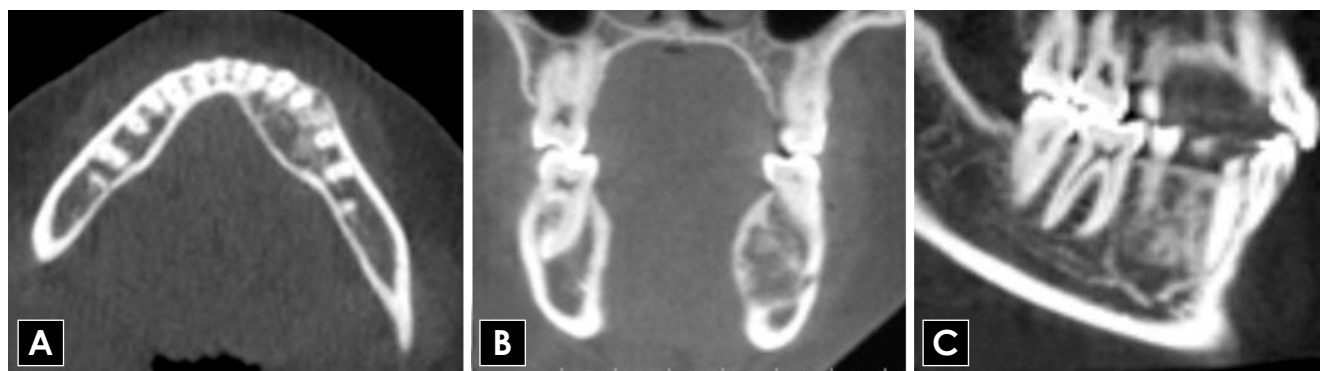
Axial (A), coronal (B), and sagittal (C) CBCT images of a hybrid CGCG with COF lesion in the left premolar region of the mandible with a well-defined, mixed-density appearance. CBCT: cone-beam computed tomography, CGCG: central giant cell granuloma, COF: central ossifying fibroma.
